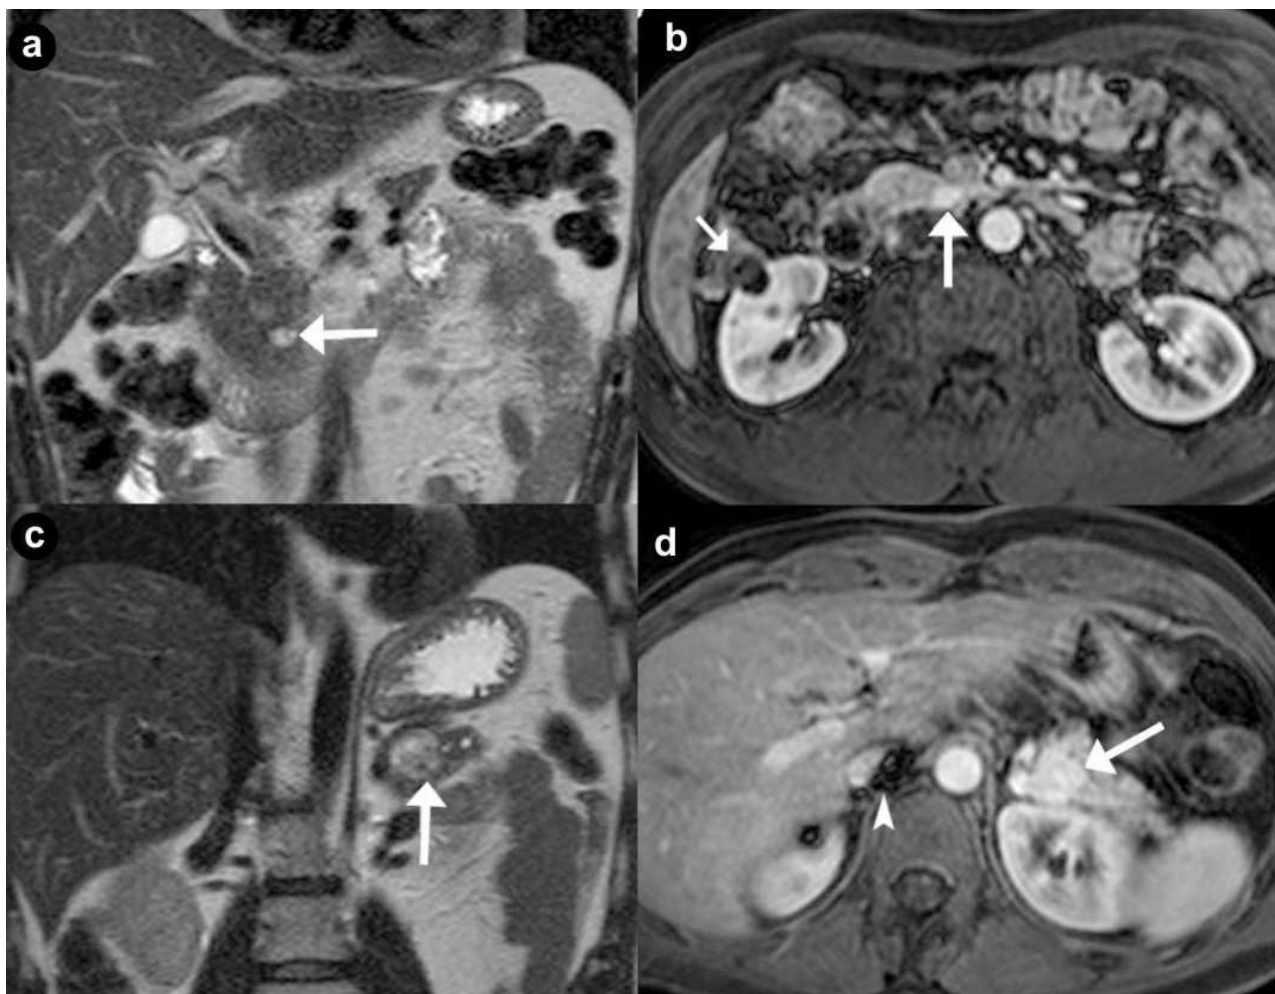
Pancreatic non functioning neuroendocrine tumors. Two cases suffering from VHL syndrome: a 39-year-old man (a. b.), and a 37-year-old man (c. d.). Coronal (a. c.) T2-weighted MR images; axial (b. d.) 3D volumetric gradient-echo T1-weighted fat suppressed images after intravenous contrast medium administration during arterial pancreatic phase of contrastographic dynamic study. In pancreatic head, a small, nodular solid lesion with maximum diameter of 12 mm (a. b. arrow), hyperintense on T2-weighted MR images, with homogeneous enhancement after intravenous contrast medium administration during arterial pancreatic phase is present. Main pancreatic duct is normal and common bile duct is not dilated. Small complex cystic mass in the right kidney without enhancement after intravenous contrast medium administration (b.) is present (short arrow). In pancreatic body-tail a solid, round mass with maximum diameter of 23 mm (c. d. arrow), heterogeneously hyperintense on T2-weighted MR images, with homogeneous enhancement after intravenous contrast medium administration during arterial pancreatic phase, is present. Artifacts are recognizable in the site of right adrenal gland (arrowhead), due to the presence of metallic staples of previous adrenalectomy for pheochromocytoma.
